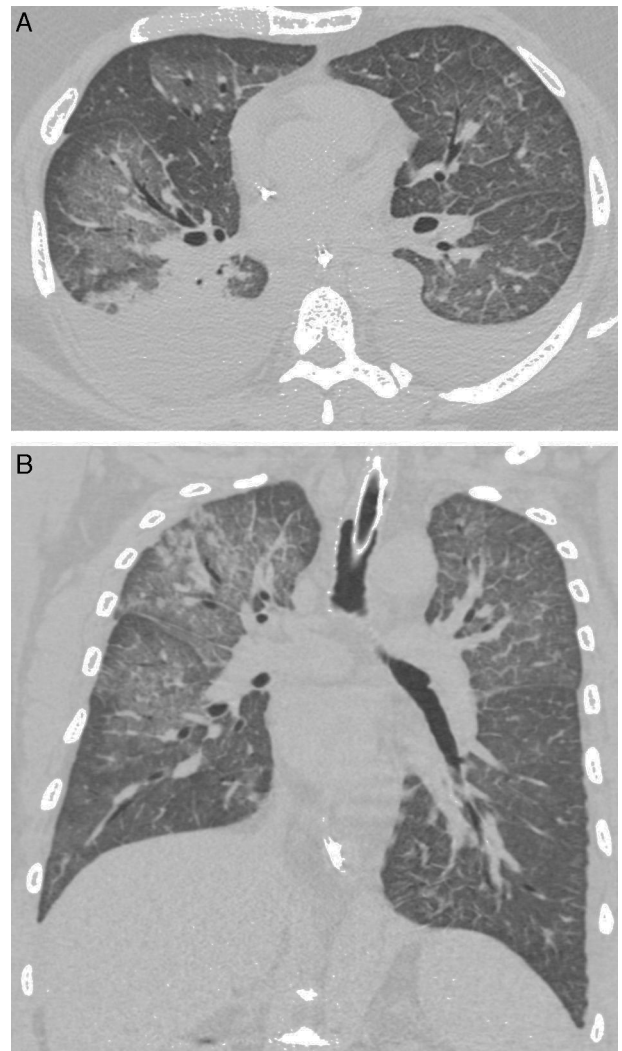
A 28-year-old man with fever and rapidly progressive dyspnea. High-resolution computed tomography with axial (A) and coronal (B) reconstructions shows bilateral ground-glass opacities. Note also bilateral pleural effusion.
